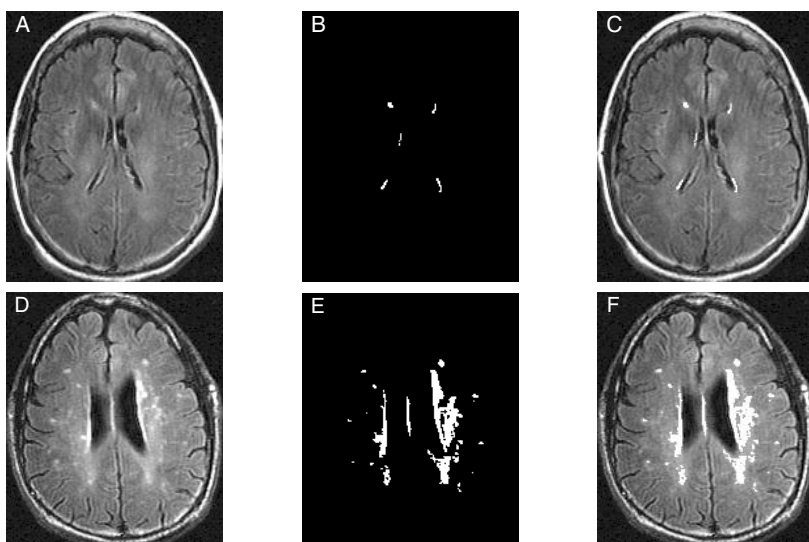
Axial slices at the level of the ventricles for a control (A, B, C) and a DM subject (D, E, F). The three columns represent the fluid-attenuation inversion recovery (FLAIR) image (A, D), the white matter changes (WMC) segmentation (B, E) and the overlay of the segmentation on the FLAIR image (C, F). Visual rating scale for continuous WMC for the control subject was 1 and for the DM subject was 3.
